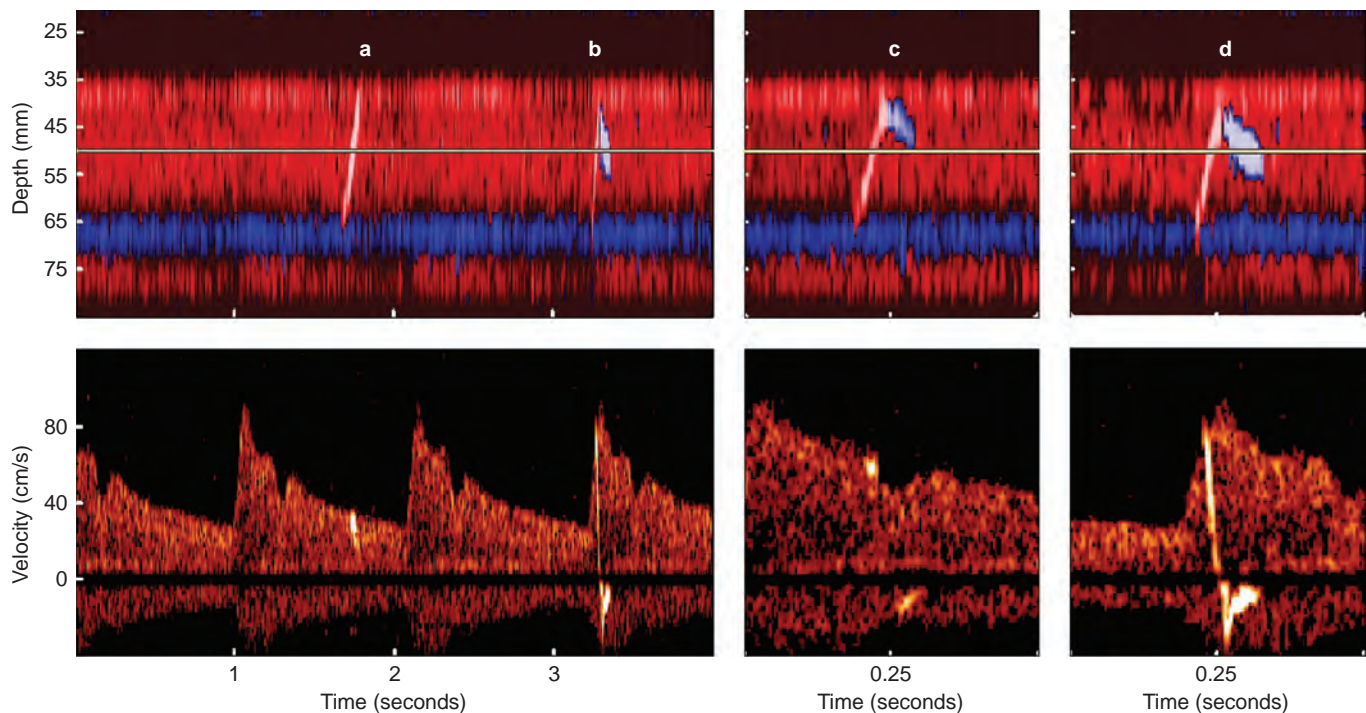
Embolic signals detected by the transcranial Doppler M-mode and spectral displays. The appearance of emboliform high-intensity transient signals (HITS) is compared using the M-mode and frequency spectral displays. The white horizontal line at a depth of 50 mm depicts the site of the spectral measurement along the axis of the vessel. HITS (white transient) represents linear migration of an embolus in the M2 segment of the ipsilateral middle cerebral artery. HITS (white dot) is noted on the spectral display as the embolus passes through the 50-mm measurement site. In contrast, emboli in the remaining panels suddenly change direction as they pass into a smaller branch vessel. HITS *b* and HITS *d* direction changes are noted on the spectral displays as the characteristic “lambda” sign. However, the HITS *c* behavior is misidentified as two emboli because the direction change occurs outside the spectral sample volume. (Courtesy Dr. Mark Moehring, Spencer Technologies, Seattle, Wash.)
